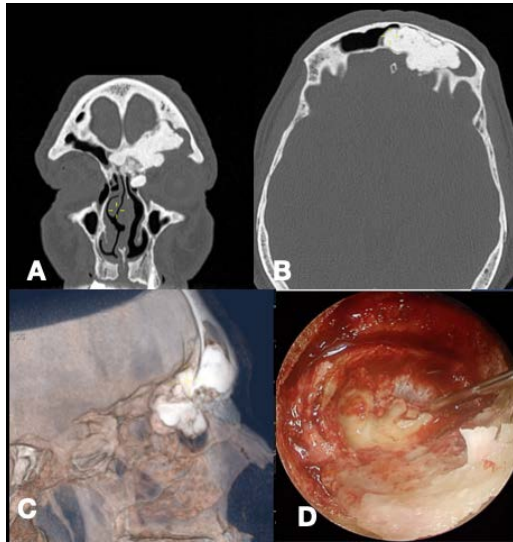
Coronal (A), axial (B), and 3D Computed tomography (CT) images of the patient diagnosed with osteoma, along with the endoscopic view of the tumor (D).
